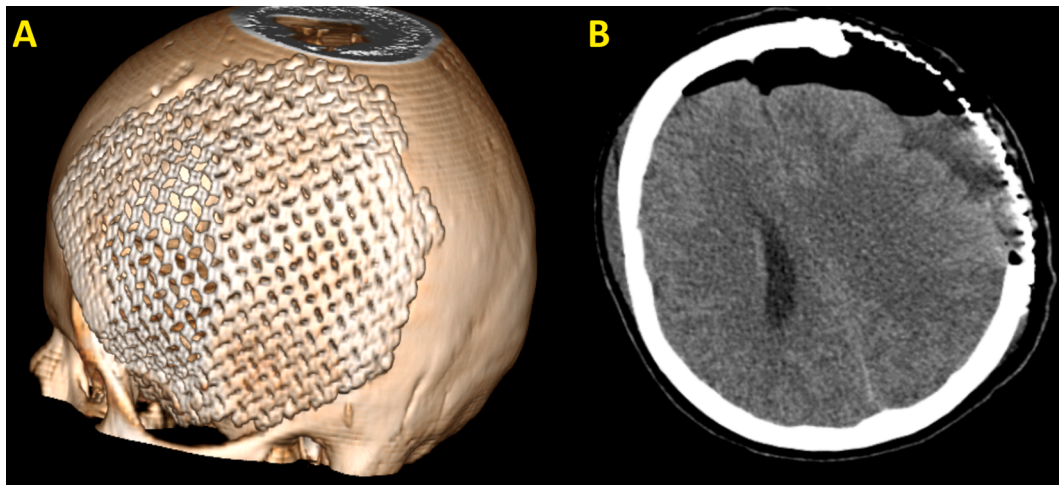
A — three-dimensional CT reconstruction. Cranioplasty with a titanium individual stereolithographic 3D implant. B — postoperative axial computed tomography. The tumor is completely removed. There is no hemorrhagic component.
